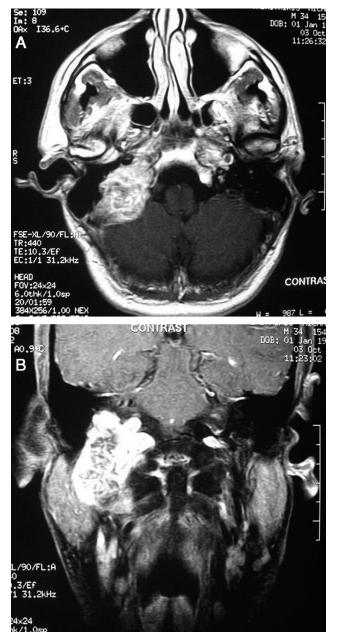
(A) Axial T1-weighted MRI scan with gadolinium showing a right jugular foramen chondrosarcoma extending to the petrous apex. The tumor shows heterogeneous enhancement and appears confined to the extradural space even if the posterior cranial fossa dura is pushed medially. (B) Coronal T1-weighted MRI scan with gadolinium of the same tumor showing the intra- and extracranial extension of the lesion (case 3).
